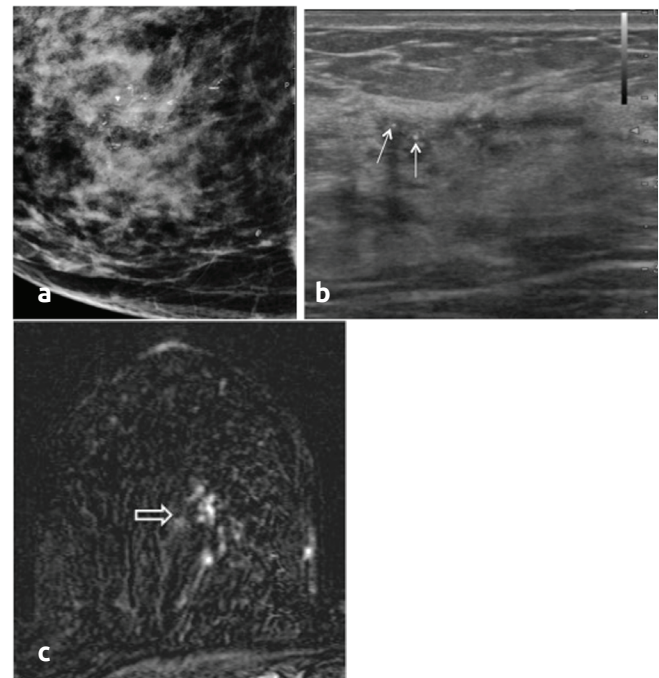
A 48-year-old asymptomatic female patient who presented with microcalcifications detected on screening mammography. a. Mammography image shows pleomorphic microcalcifications with segmental distribution. b. US shows microcalcifications (arrows) within irregularly dilated ducts, which appear as bright intraductal echoes. c. Axial post-contrast subtraction MR image shows clumped NME with segmental distribution (open arrow). High grade DCIS with RC was diagnosed using US-guided core biopsy. Microinvasion was detected on surgical excision. Both the estrogen and progesterone receptors were positive, HER2 was negative and the Ki-67 index was more than 20%
